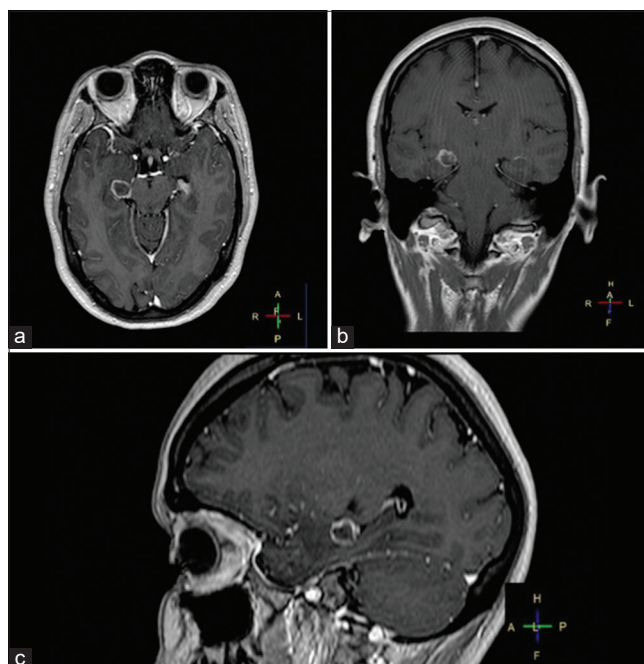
Pre-operative axial (a), coronal (b), and sagittal (c) post-contrast T1-weighted MR showing a right temporo-mesial lesion with an irregular peripheral enhancement.
